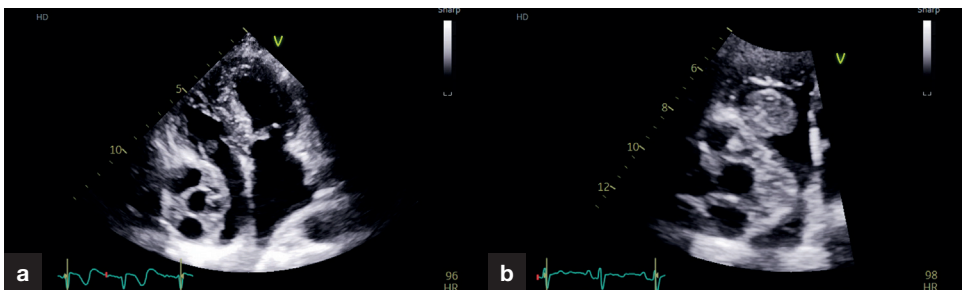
Transthoracic echocardiography in 2022. a. Four-chamber view showing a polycystic mass compressing the right atrium. b. Zoomed four-chamber view showing the polycystic mass compressing the right atrium and a solid intra-atrial mass highly suspicious of thrombus.
